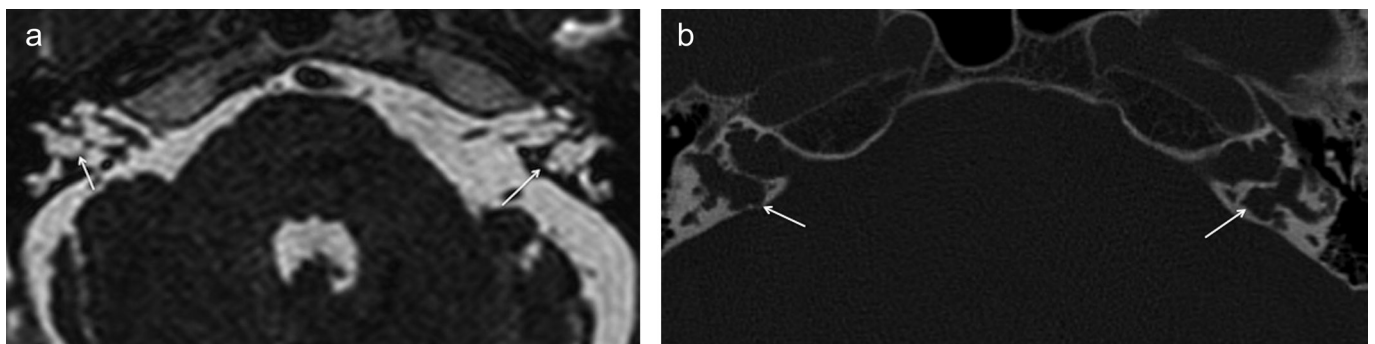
a, b. A 53-year-old male patient with XLD and bilateral typical IP-III. The CT (a) and MR (b) images demonstrate fluid-filled cavities/cystic structures (arrows) surrounding the vestibules and SCCs.
